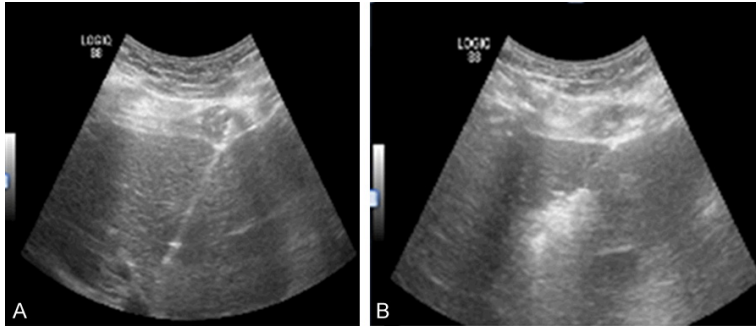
Ultrasonography image of the tumor. A. MW ablation probe with ultrasonography is located in the metastatic lesion. B. The appearance of the same lesion on USG after ablation.
